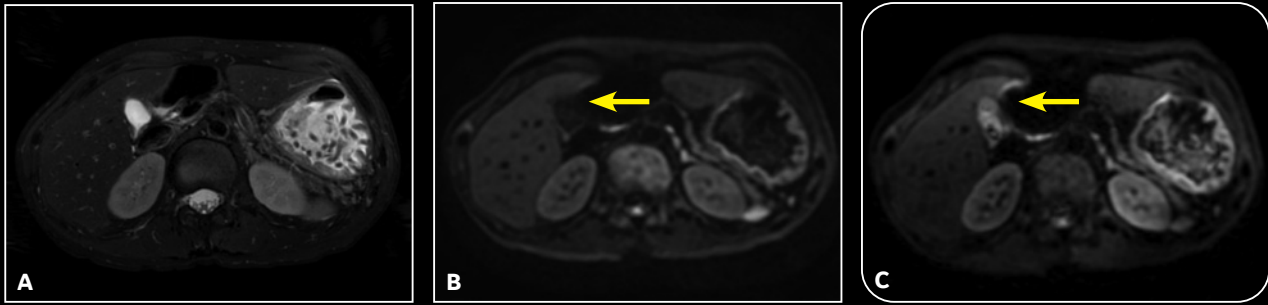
Low distortion DWI is achieved with MUSE. (A) Axial T2w FSE, FOV 30 cm, Th/Sp 5 mm/1 mm, 320 x 320 in a scan time of 2:49 min. (B) Axial MUSE with b1000, FOV 36 cm, Th/Sp 4 mm/1 mm, 128 x 160, shot 2, ASSET 2 in a scan time of 3:30 min. (C) Axial DWI EPI with b1000, FOV 36 cm, Th/Sp 4 mm/1 mm, 128 x 160, ASSET 2 in a scan time of 2:30 min.
